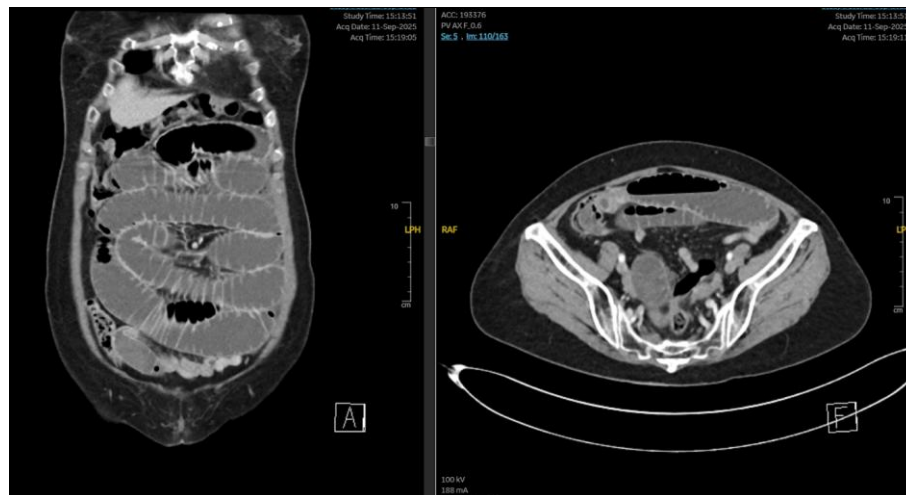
Contrast-enhanced CT of the abdomen and pelvis demonstrating a transition point in the distal ileum.
